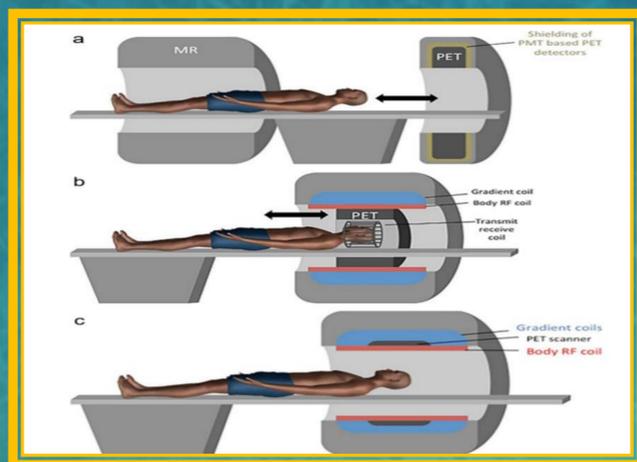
Types of PET MRI Configurations.³
